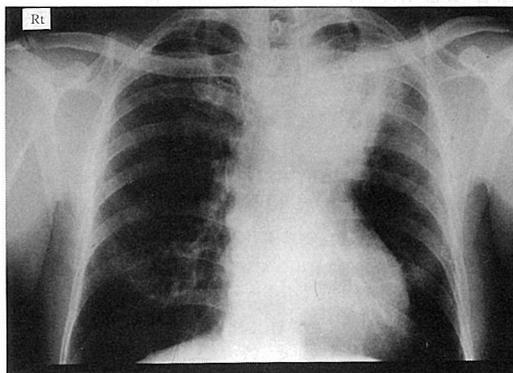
Chest radiography showed a massive consolidation adjacent to aortic arch in the left upper lobe and segmental consolidation in the right upper lobe.
